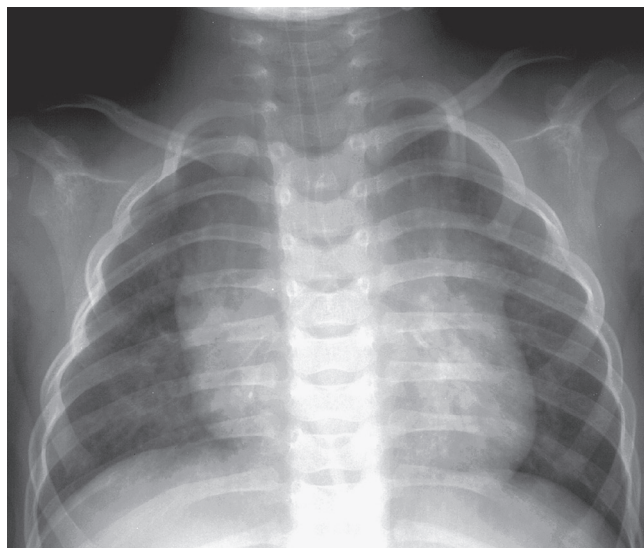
■ Tracheal stenosis (stovepipe trachea) in a 20-month-old boy with stridor since birth. Frontal chest radiograph shows a diffusely narrowed trachea faintly outlined by water-soluble contrast medium. (Courtesy Simon C. Kao, MD, Iowa City, IA.)
